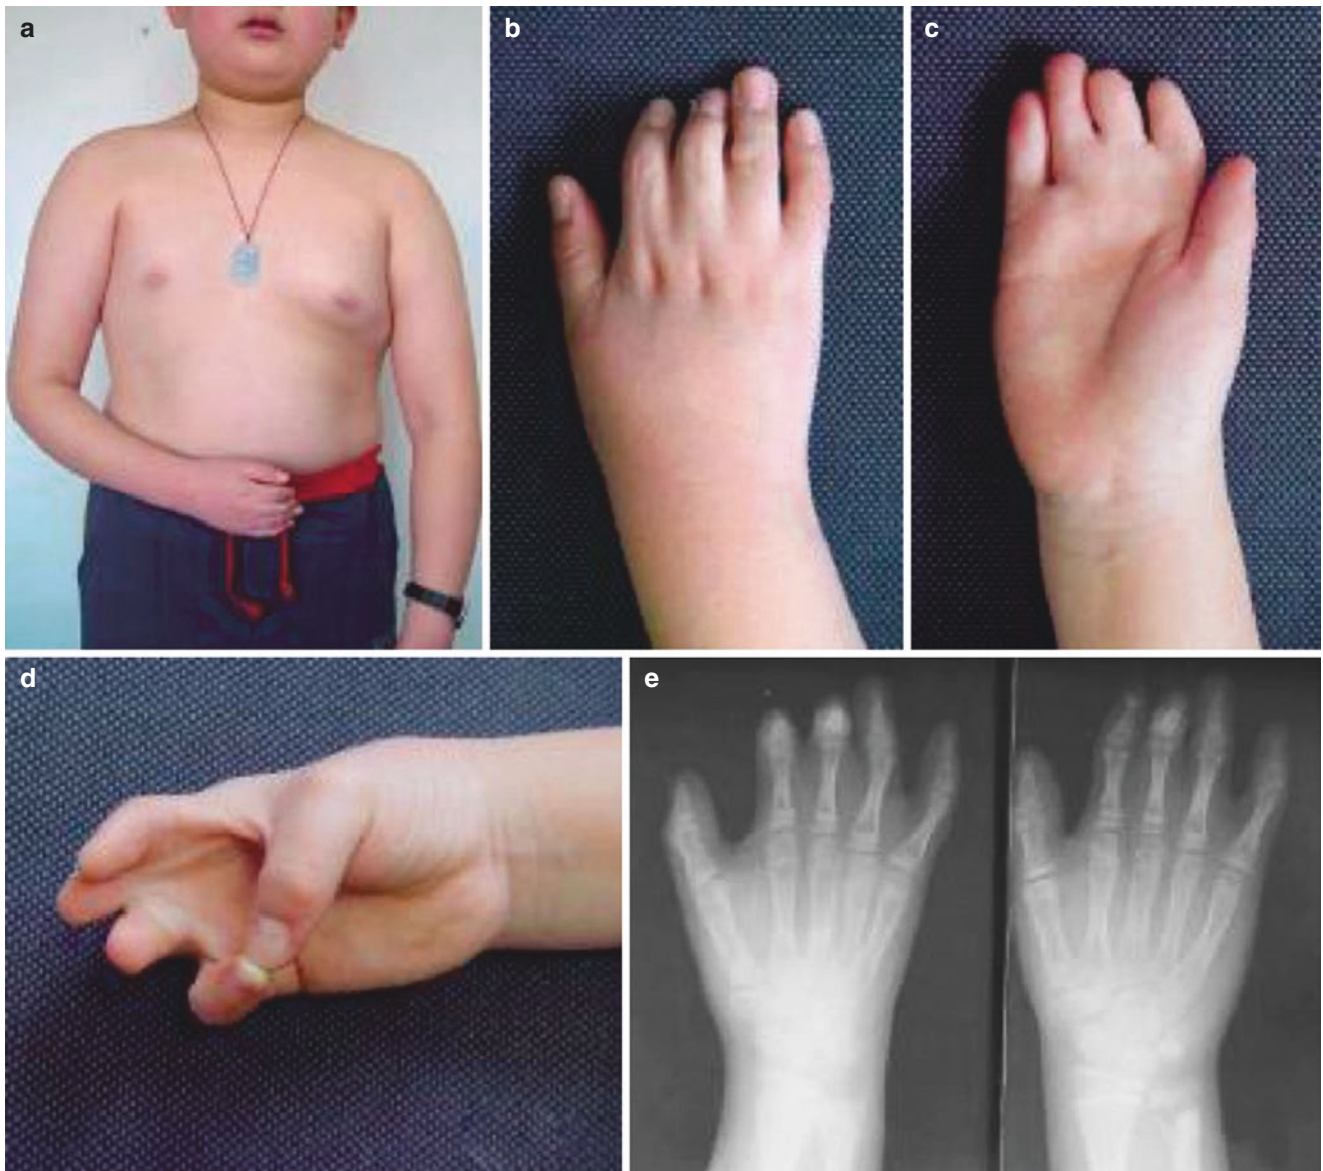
Brachydactyly and syndactyly accompanied by absence of pectoral muscle (Poland syndrome). (a) Physical appearance. (b–d) Hand appearance. (e) Hand X-ray findings
